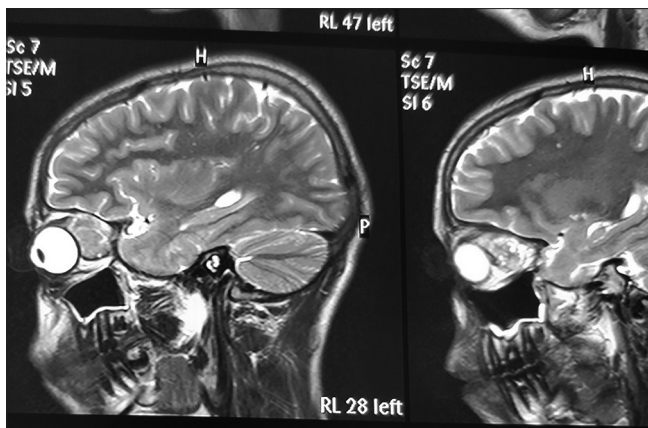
Magnetic resonance imaging T2-weighted sagittal image showing heterogeneously hyperintense lesion
